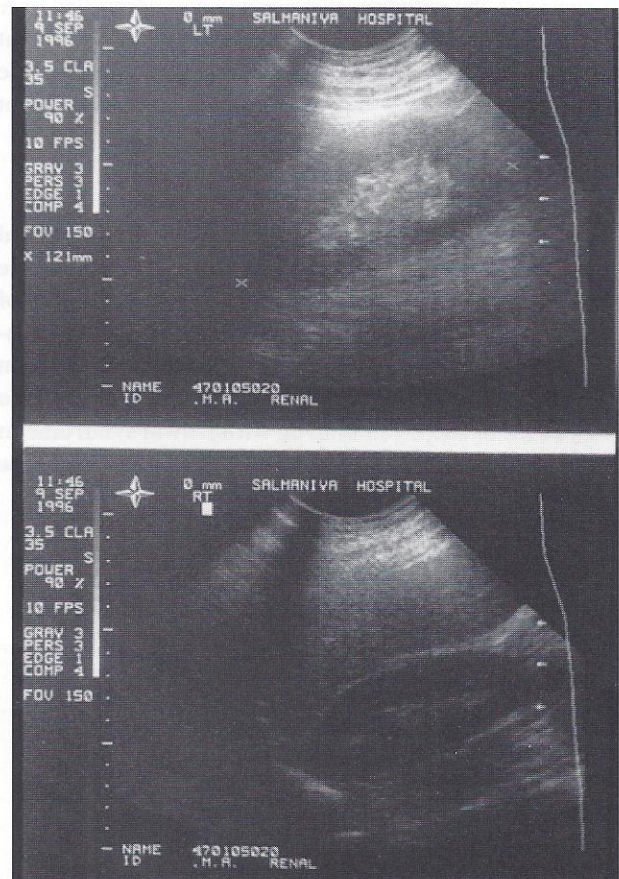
Renal sonography showing swollen left kidney
